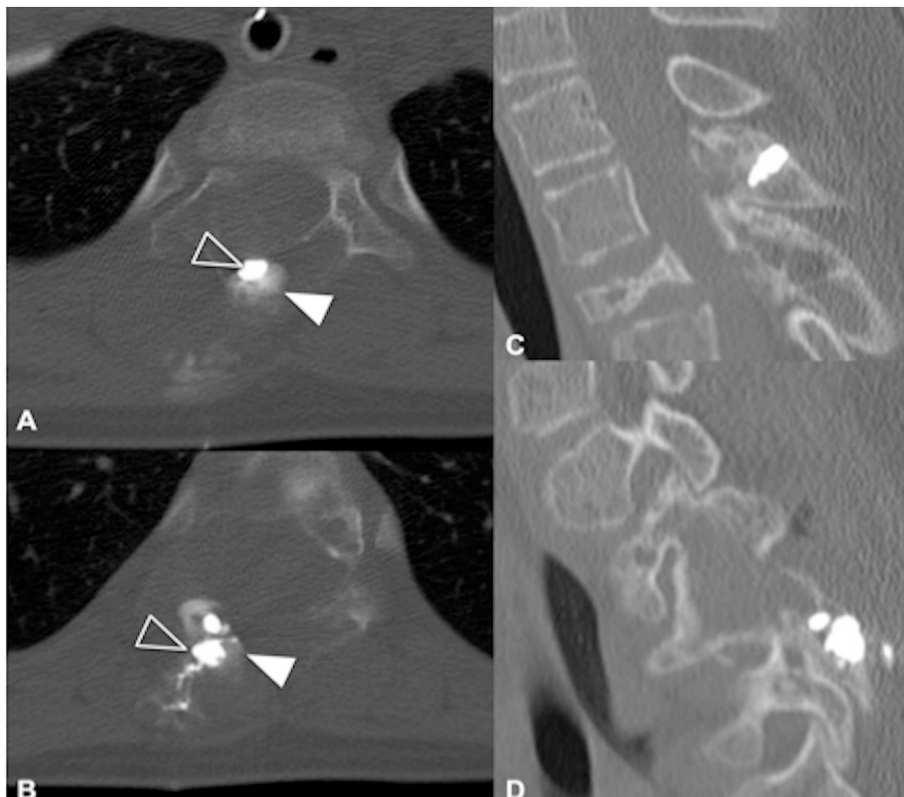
Axial intra-operative CT-scan showing the site of injection of iodine contrast in the posterior arch of the T3 (A) and T4 (B) vertebrae (white arrowhead) followed by injection of a small amount of PMMA (empty arrowhead). Monitoring CT-scan at 6 months (C & D) showing placement of cement in the posterior arches of the treated vertebrae.
